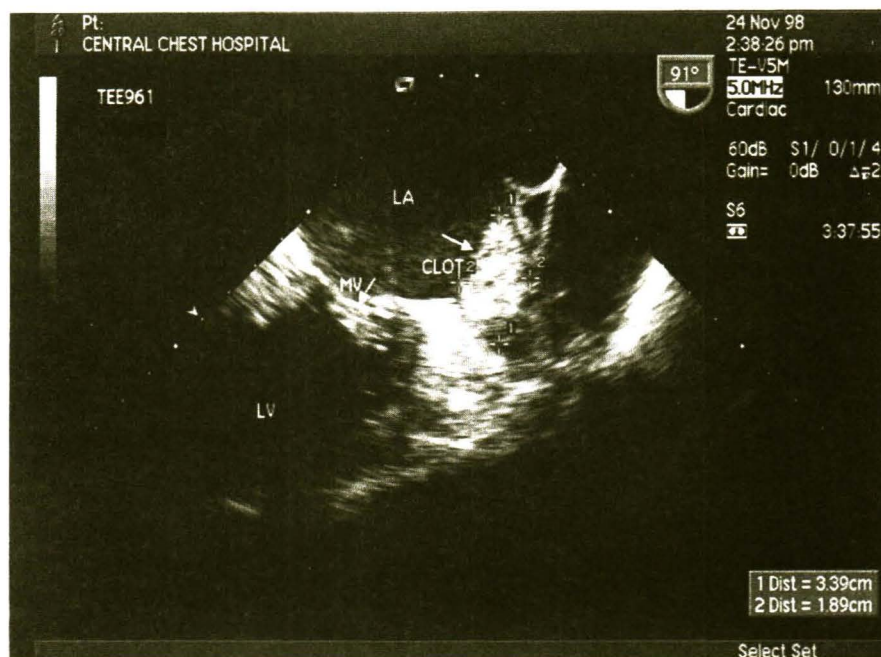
Transesophageal echo shows clot in left atrial appendage, size 3.39 x 1.89 cm. LA = left atrium, MV = mitral valve, LV = left ventricle.
